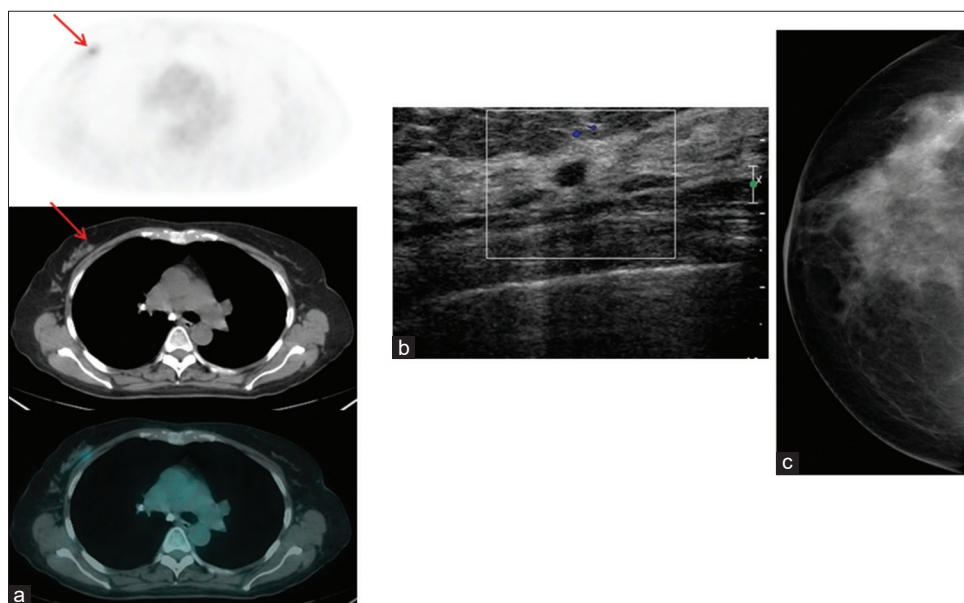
A 57-year-old female with a history of adenocarcinoma of the head of the pancreas. Staging ¹⁸F-fluorodeoxyglucose positron emission tomography/computed tomography (a) revealing hypermetabolic lesion in the right breast (red arrow). Ultrasound (b) revealing 0.5 cm x 0.4 cm hypoechoic lesion without increased vascularity. Her mammogram (c) was not conclusive. Biopsy revealed invasive duct carcinoma
